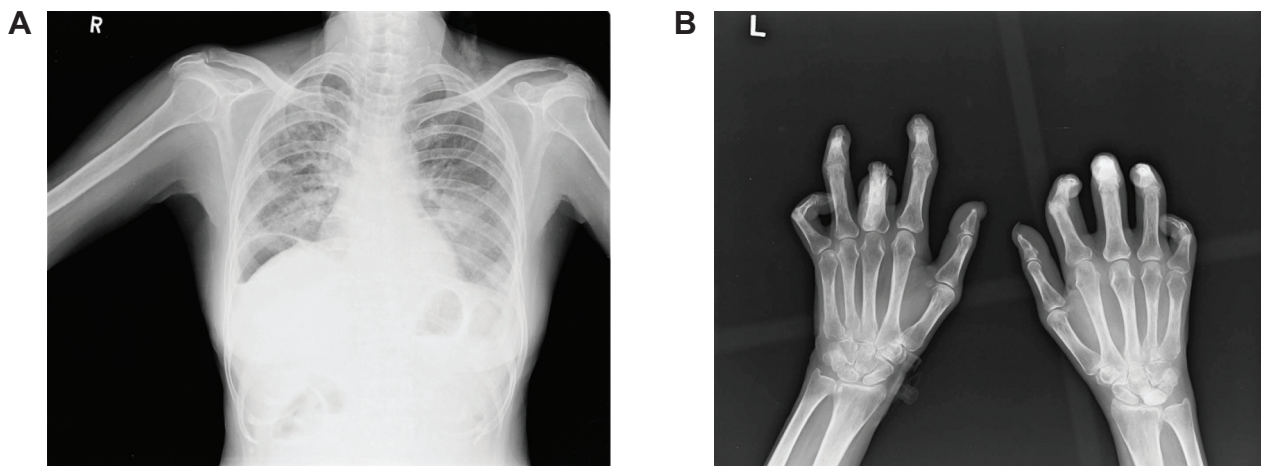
X-ray of the chest (A) and hand (B).
